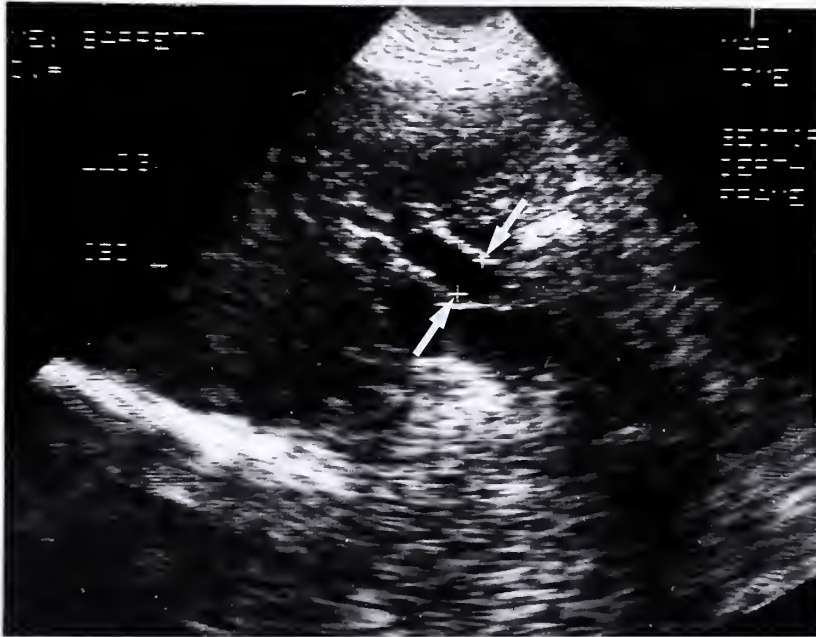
Subject #4: Ultrasound image demonstrating a dilated common bile duct measuring 8 mm (normal = 6 mm or less). Arrows point to cursors used to measure duct diameter.
